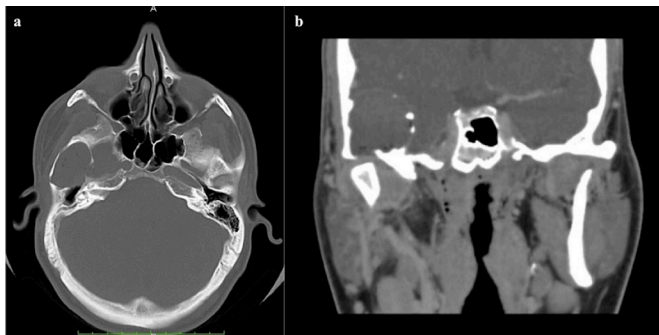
Preoperative CT-scan, axial (A) and coronal (B) planes showing erosion of the temporal bone and of the middle fossa plate with involvement of the glenoid fossa.
